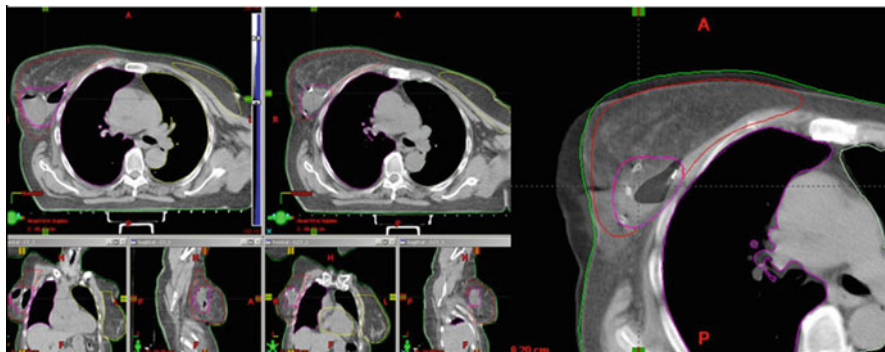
The seroma volume changes during whole-breast RT affect the volume of normal breast tissue and the accuracy of boost planning. Therefore, CT-based boost planning is recommended before boost irradiation to ensure appropriate coverage
